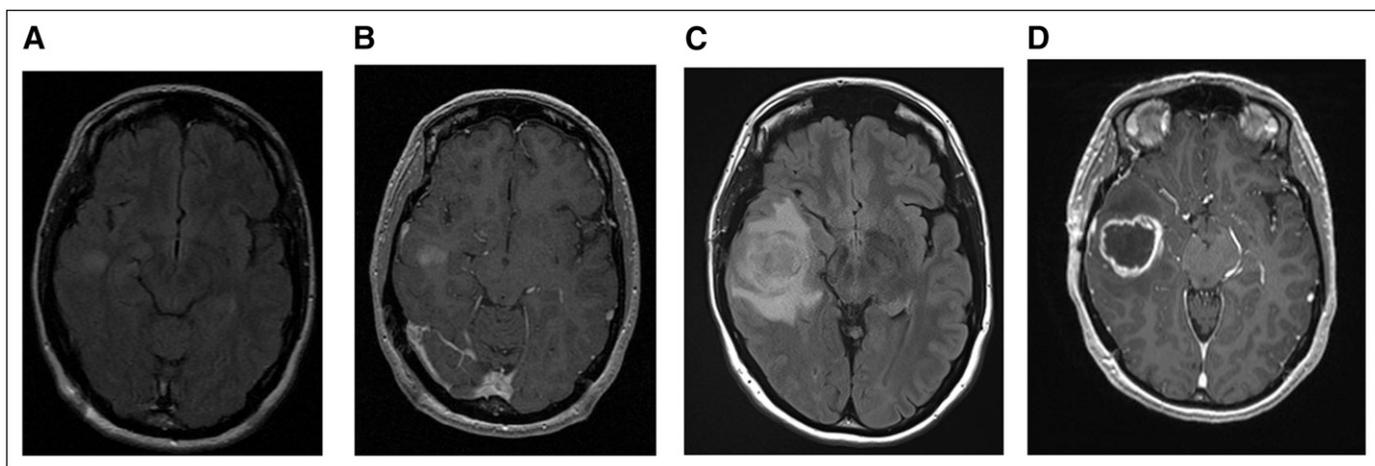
Magnetic resonance (MR) images of a patient with new-onset seizure. (A, B) Small lesion in the right temporal lobe with faint enhancement and no edema. (C, D) Repeat MR images 20 days later with rapid evolution to a large ring-enhancing mass with a necrotic center and significant perilesional edema. Pathology showed glioblastoma.
